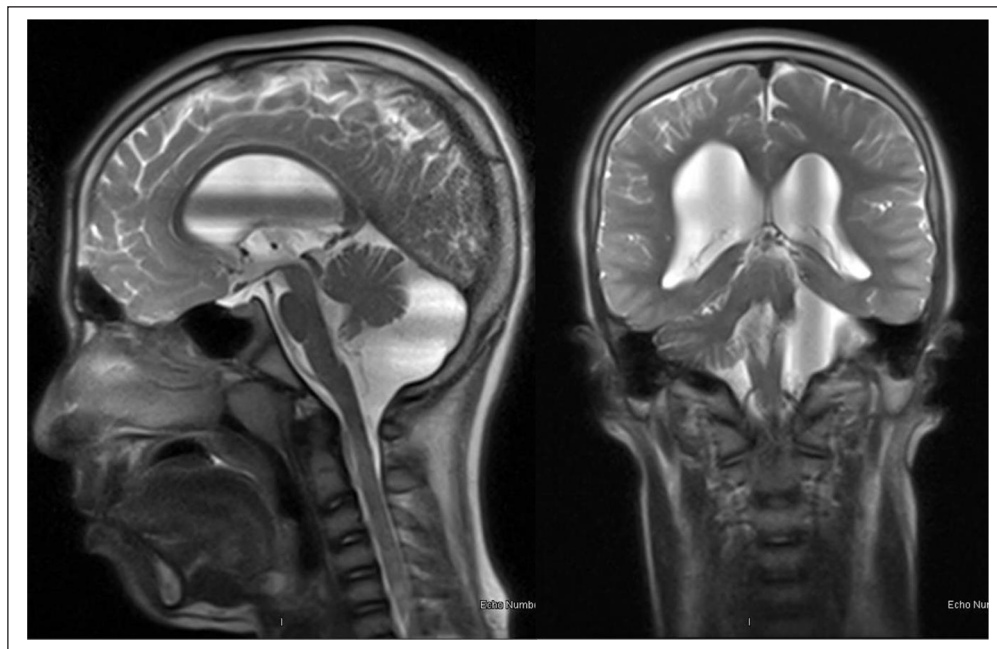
Magnetic resonance imaging scan of the patient showing the appearance of DWM.
